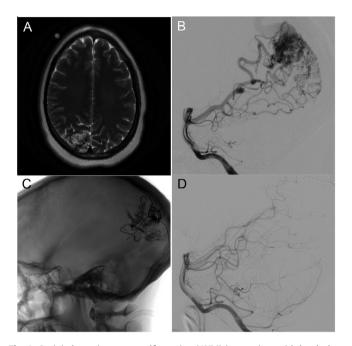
Occipital arteriovenous malformation (AVM) in a patient with headaches. Preoperative T2-weighted axial MRI demonstrates flow voids in the right parietooccipital region consistent with a brain AVM (A). Left vertebral arteriogram in lateral projection confirms a 3 cm AVM arising from distal branches of the right posterior cerebral artery (B). Later skull radiograph shows radio-opaque glue cast after preoperative n-butyl cyanoacrylate (NBCA) embolization (C). Postoperative catheter angiography after vertebral artery injection confirms that a complete resection of the AVM was accomplished (D).
